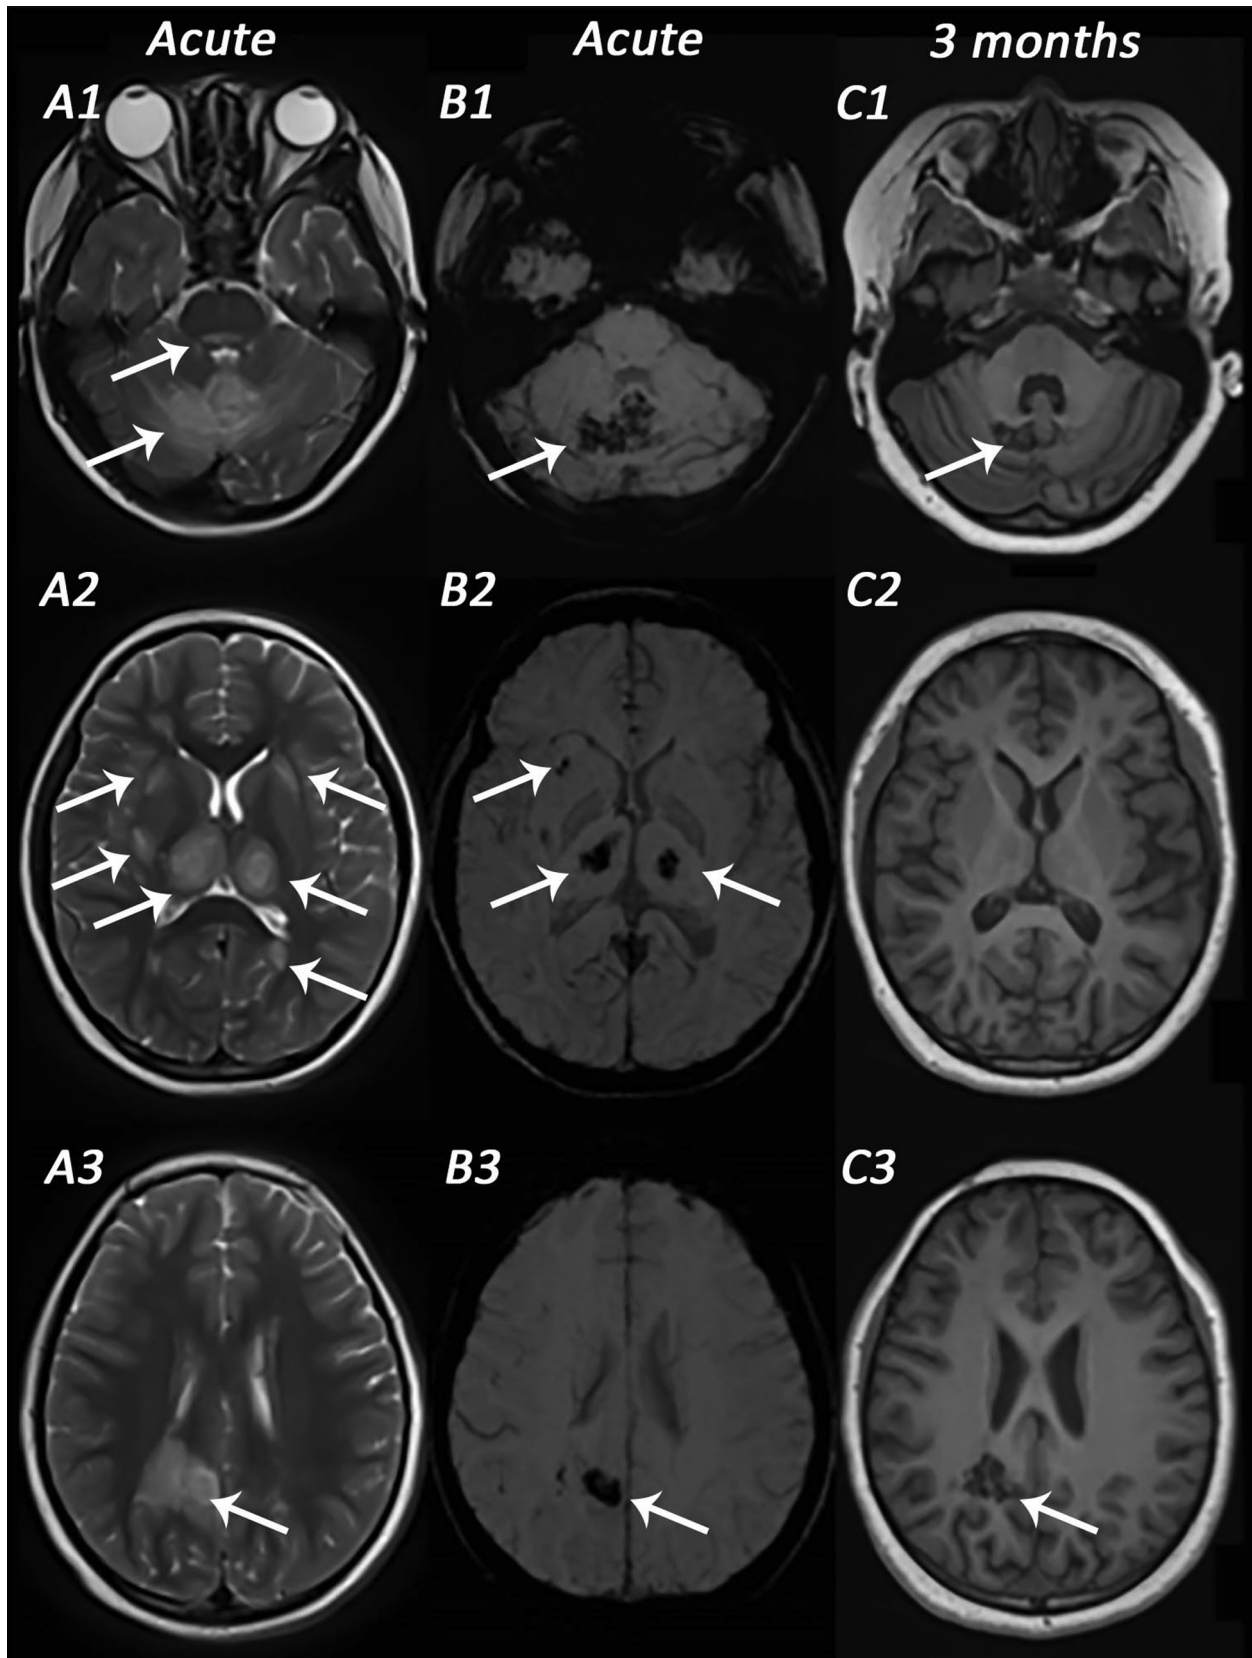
Magnetic resonance brain imaging for Patient 3 with a mild disability outcome. A, B images at acute illness: A1-A3, axial T2-weighted images. Hyperintense lesions in the pontine tegmentum, cerebellar white matter and vermis, bilateral thalami, external and internal capsule, and cerebral white matter (white arrows). B1-B3, axial susceptibility weighted images. Blooming artifact indicating hemorrhage in the cerebellar white matter, vermis, bilateral thalami, external capsule, and cerebral white matter (white arrows). Multifocal punctate microhemorrhages were also observed in the cerebral hemispheres bilaterally. C1-C3 images, at three months follow-up. Axial T1-weighted imaging (angle of slices differs slightly from A and B images). Focal encephalomalacia in the right parieto-occipital and cerebellar white matter (white arrows). Both thalami appear normal.
